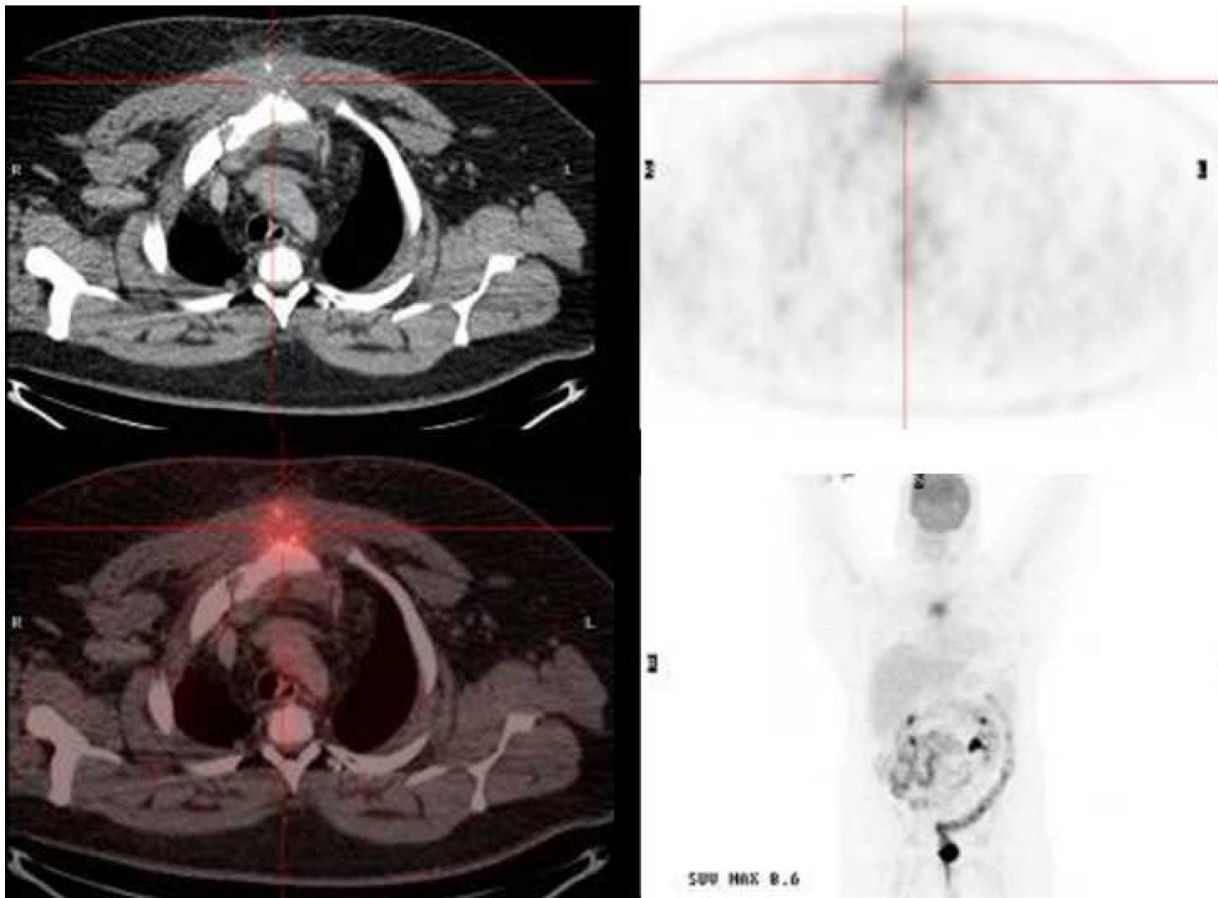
Thoracic computed tomography scan shows destructive sternal bone lesion associated with a soft tissue mass (approximate size 96 mm × 71 mm × 53 mm) with a hypermetabolic lytic lesion at the manubrium–sternal junction, associated to a mass of perilesional soft. tissues, and infiltration of the upper mediastinal fat with a SUV max value of 8.6.
